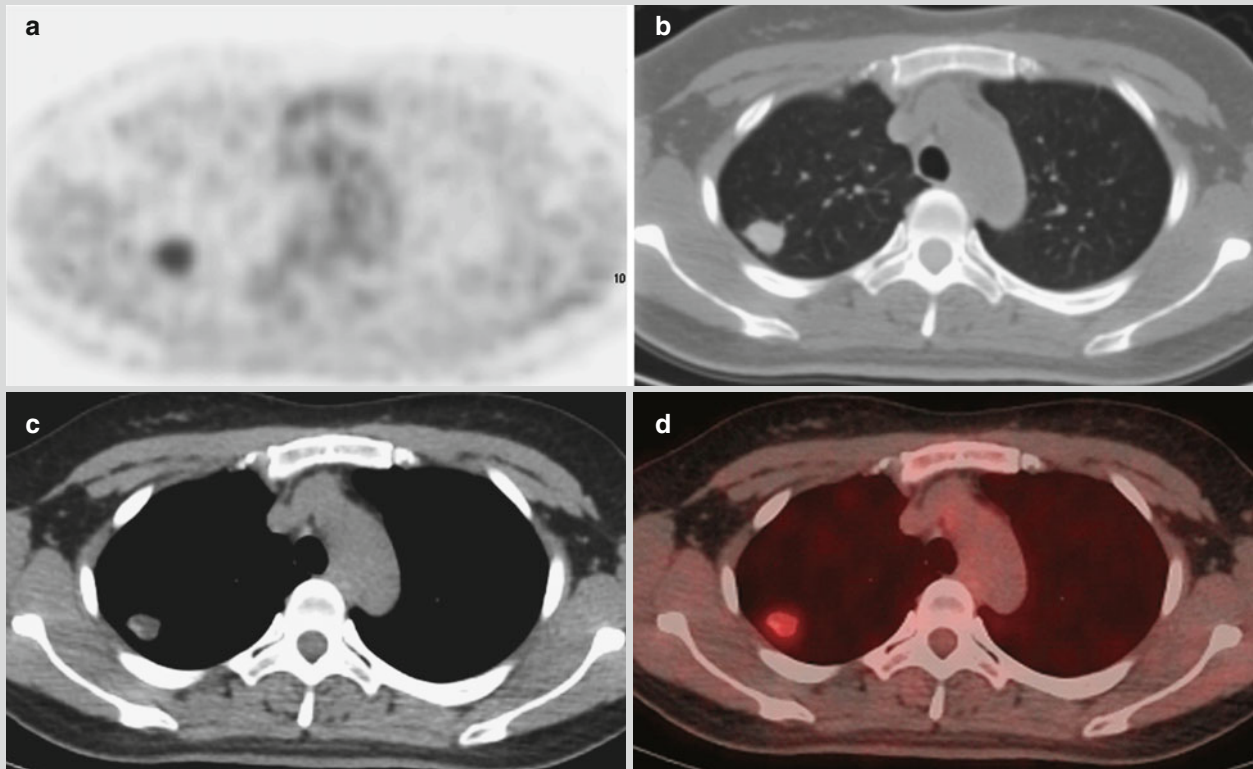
Tuberculoma. (a) PET demonstrates increased radioactive uptake by nodules at the right upper lung lobe, with SUV max 2.9. (b, c) CT scanning demonstrates a nodule in size of 1.7 cm ×
